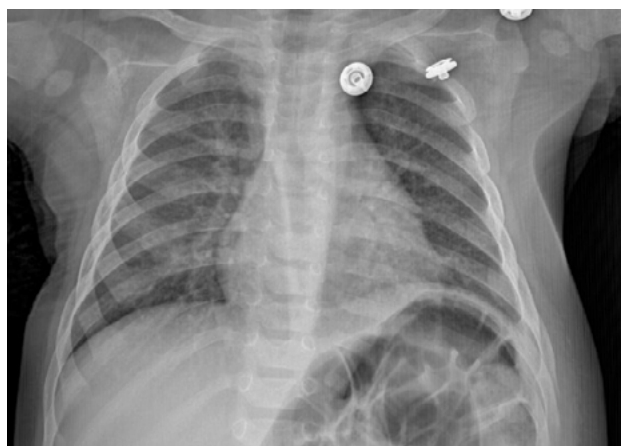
A chest radiograph showing a discreet soft parts thickening of the lower left chest wall (white arrow)
